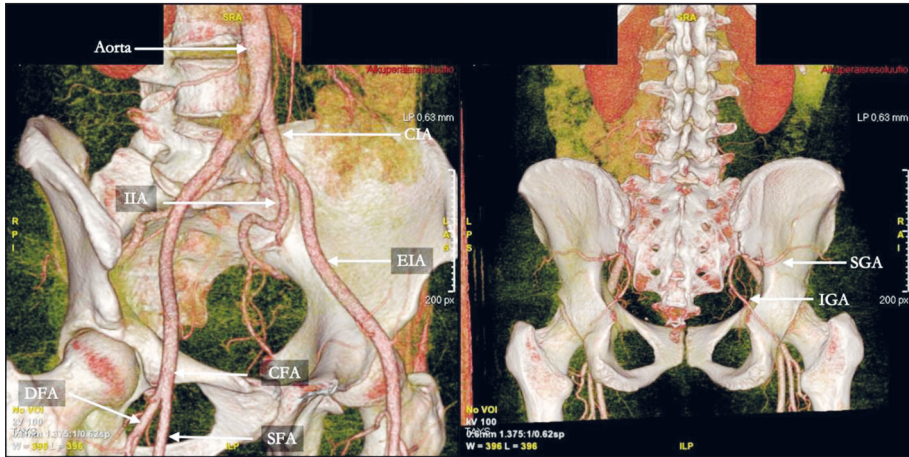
Oblique (left) and posterior (right) view of the major pelvic arteries on 3D-reconstruction of an angio-CT.
